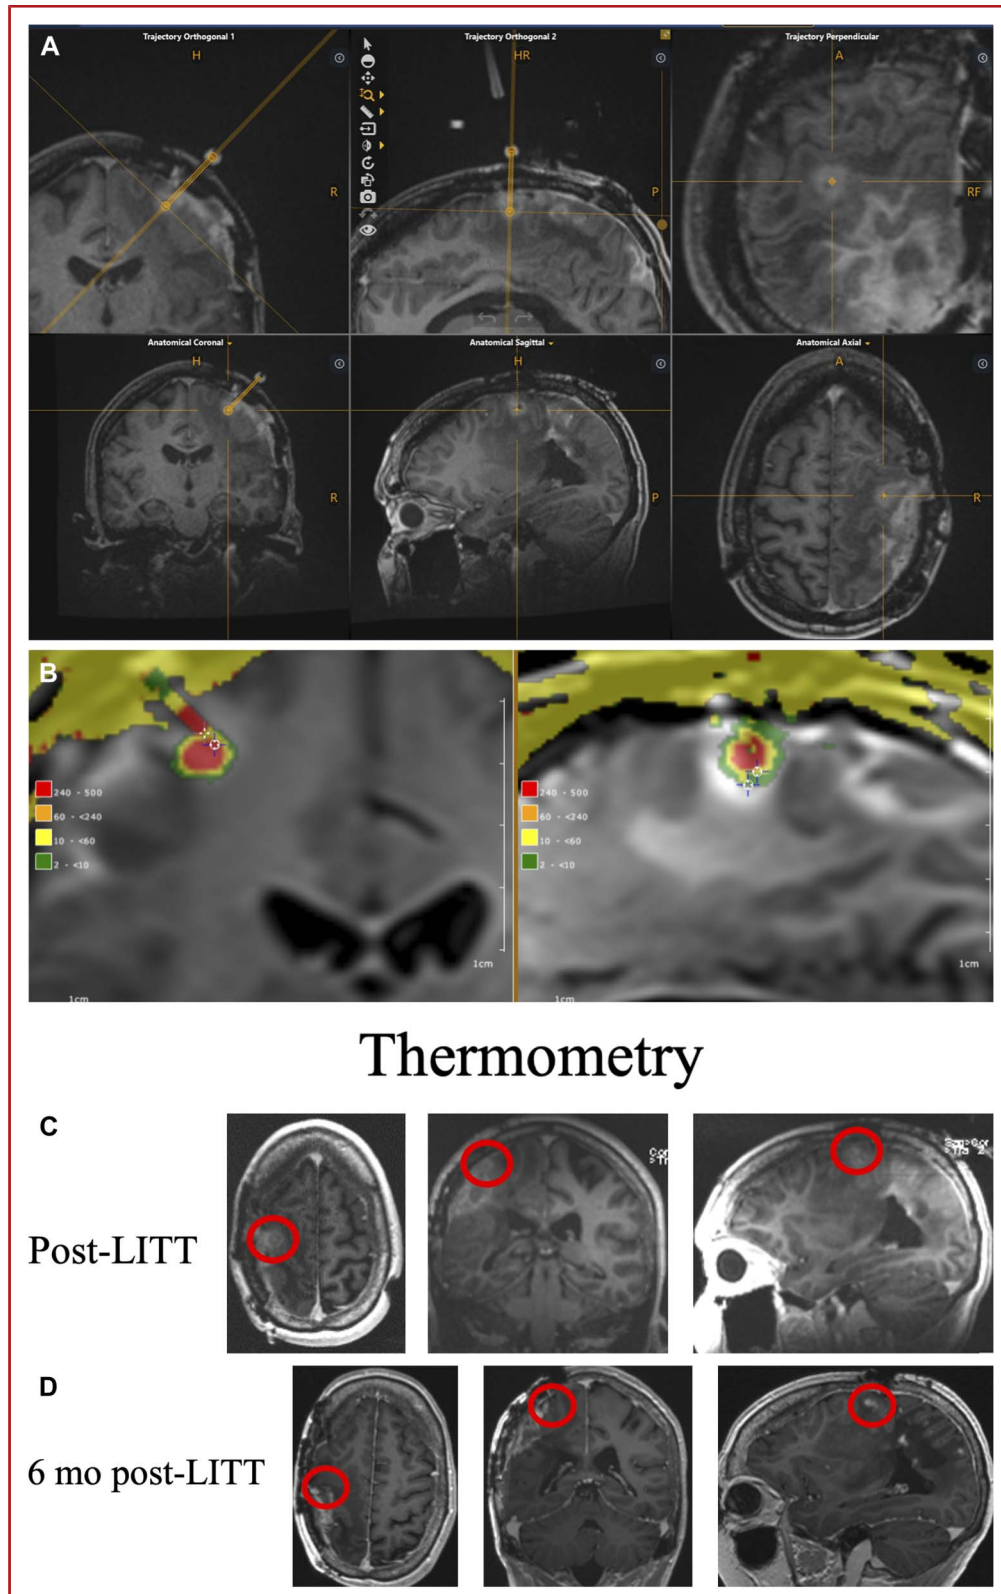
A 55-year-old woman with stage IV esophageal cancer with progressive enlargement of a right frontal contrast-enhancing area 25 months after involved field radiation therapy. A, Multiplanar postcontrast MRI images (T1 with gadolinium) demonstrating stereotactic localization and right frontal-insular approach to the target lesion. From right to left, top row: axial, sagittal, sagittal images; The top row shows the planned trajectory superimposed onto the anatomic images (orange). B, Intraoperative thermometry with the 1-mm radial probe. The ablation cavity measured 9.5 × 10 mm, encompassing 100% of the target lesion. See Figure 1D for thermometric assessment. C, Immediate, postoperative axial, coronal, and sagittal MRI images (T1 with gadolinium) demonstrating expected ablation cavity. D, Six months postoperative postcontrast axial, coronal, and sagittal MR images (T1 with gadolinium). LITT, laser interstitial thermal therapy.
